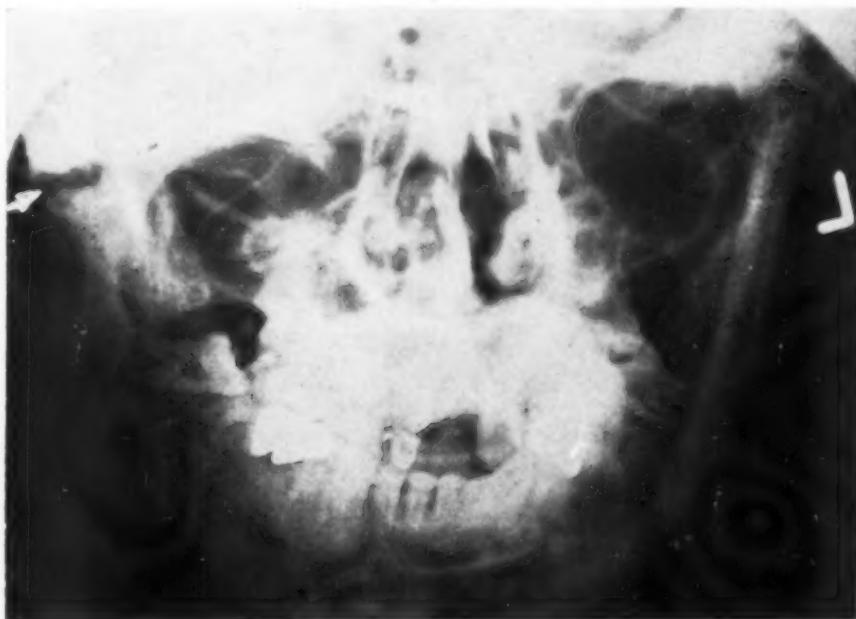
X-ray film showing pseudoarthrosis of right mandibular joint.
